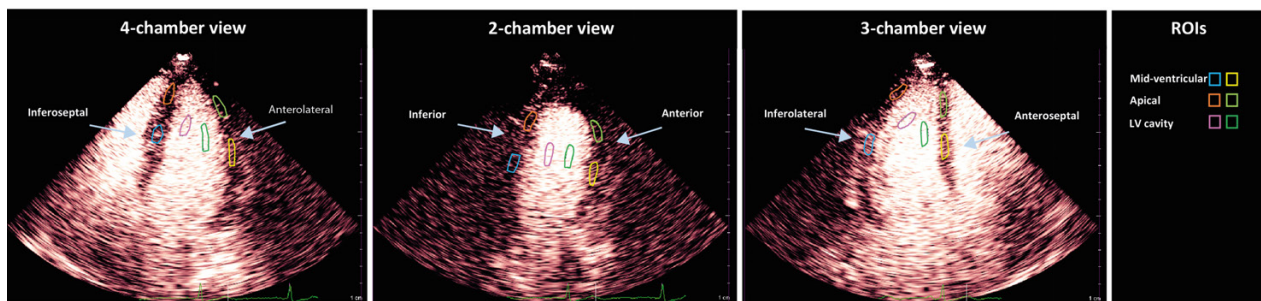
Myocardial contrast echocardiography was performed in apical 4-chamber, 2-chamber and 3-chamber views, of which regions of interest were derived in correspondence with the perfusion areas of the main coronary arteries. Abbreviations: ROIs; Region of interest, LV; Left Ventricle
